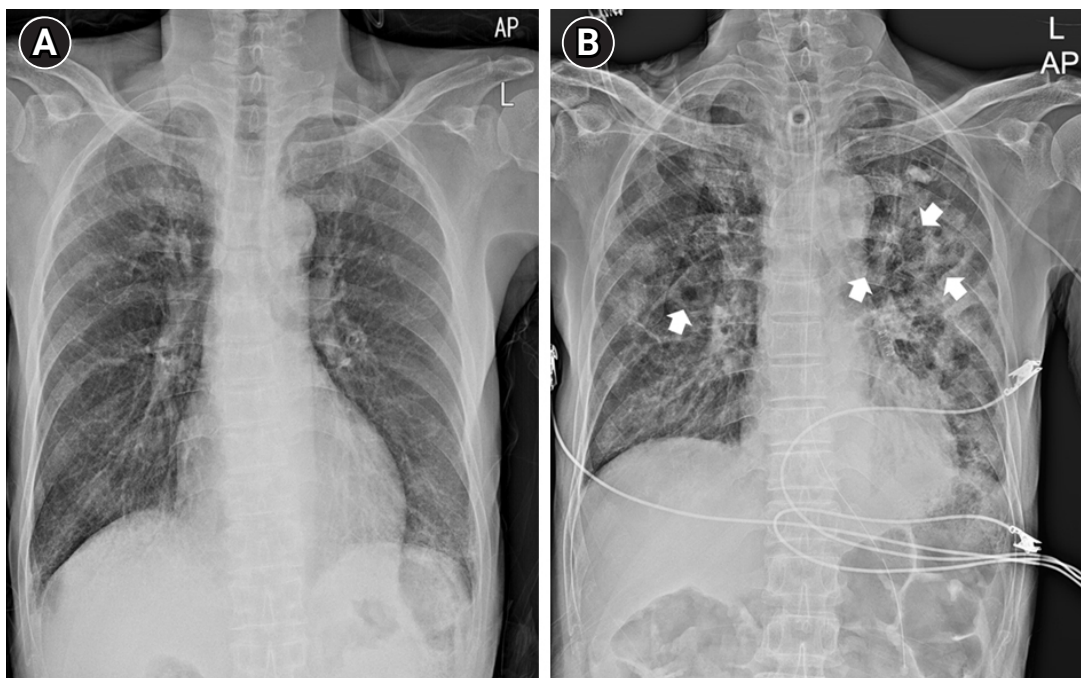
(A) Chest radiograph showing diffuse, ill-defined increased opacity in the peripheral portion of the right upper and both lower lung zones at admission. (B) Worsening of the radiograph findings showing that new bilateral patchy and ill-defined nodular consolidations and suspicious cavities (arrows) developed in both lungs. Consolidations and cavities were the most severe in the left upper to middle lung zones at time of re-intubation and tracheostomy.
